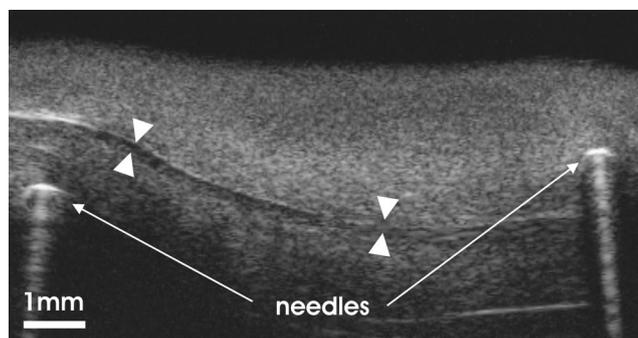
Visualization of the boundary (indicated by arrows) between the lamina propria and muscle in the longitudinal plane. Greater brightness of boundary above the left needle is because of its normal angle to ultrasound beam. Two reference marker needles, shown in Figure 1, are visible as bright arcs in cross section, followed by echo artifacts deeper into the tissue.
